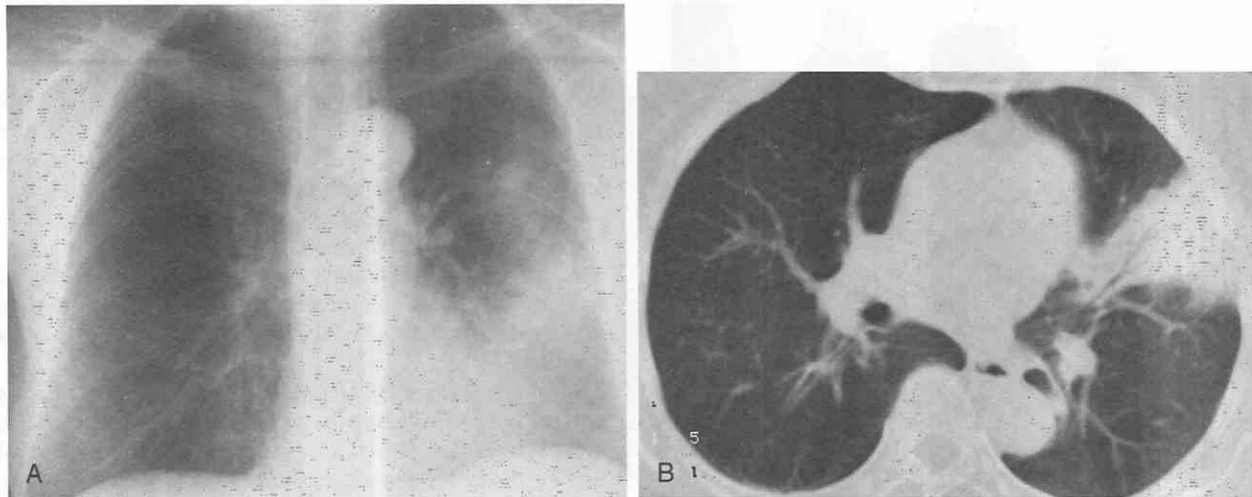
Primary pulmonary lymphoma seen as chronic consolidation. *A*, Posteroanterior chest radiograph shows a poorly margined opacity in the left lung. Note the absence of hilar and mediastinal adenopathy. *B*, CT shows a homogeneous opacity containing air-bronchograms in the left upper lobe.
